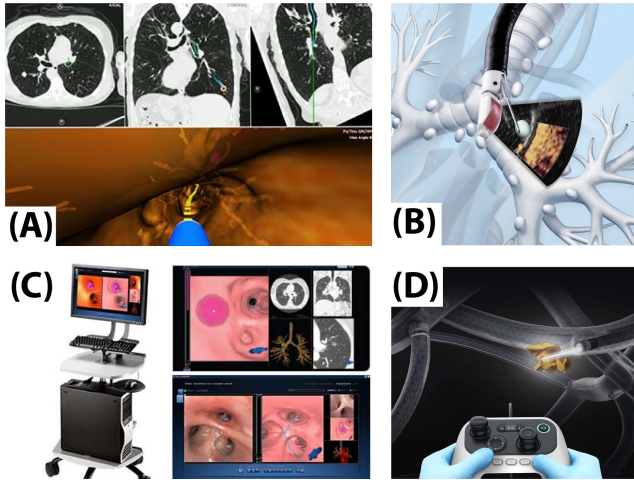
Commercial approaches to peripheral lung biopsy: (a) electromagnetic navigation (SPiNDrive, Veran Medical), (b) endobronchial ultrasound (EBUS Bronchoscope, Olympus), (c) virtual bronchoscopy (Archimedes, Broncus Medical), (d) robotic bronchoscopy (Monarch, Auris Inc.)
